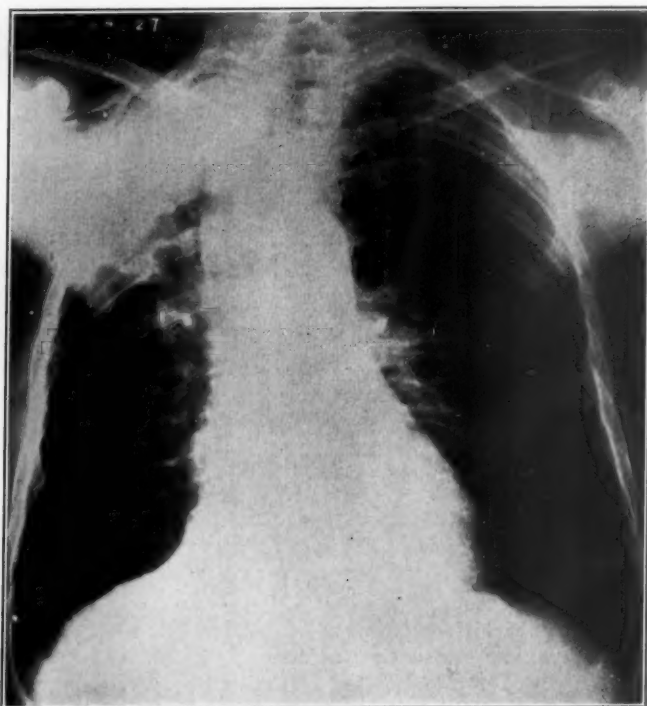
Roentgenogram taken April 16, 1934. Note lesion in right apex with displacement of trachea and mediastinum to the right; also essentially normal cardiac shadow.
